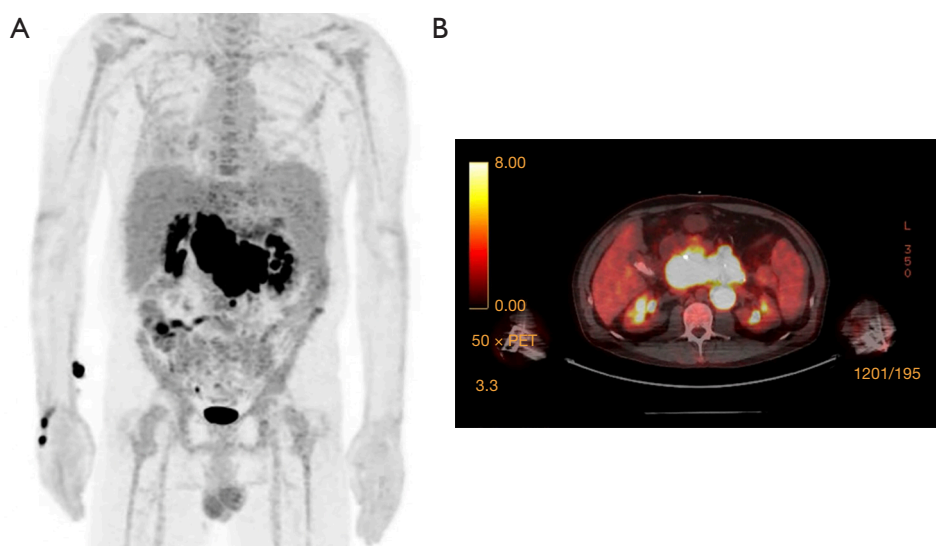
3D MIP PET and axial fused PET/CT imaging of duodenal mass. (A) 3D MIP PET image of duodenal mass. Whole-body anterior projection image of FDG-PET examination demonstrating FDG uptake in the duodenal wall extending from the 2nd–4th portion of the duodenum. (B) Axial fusion image of FDG-PET/CT showing metabolically active lesion of the duodenum with SUV_{max} of 26.4. There is also mild surrounding mesenteric fat stranding and epigastric, retroperitoneal and periaortic lymphadenopathy which are PET-avid suggestive of metastasis. MIP, maximum intensity projection; PET, positron emission tomography; CT, computed tomography; FDG, fluorodeoxyglucose; SUV, standardized uptake value.
